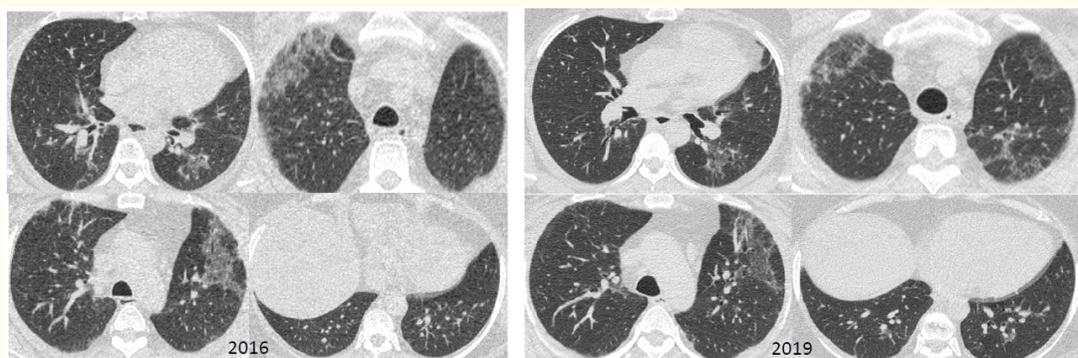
CT scan images from 2016 (left) and 2019 (right) showing ground-glass opacities, septal thickening, no basal honeycombing. Minimal change noted over 3 years.
